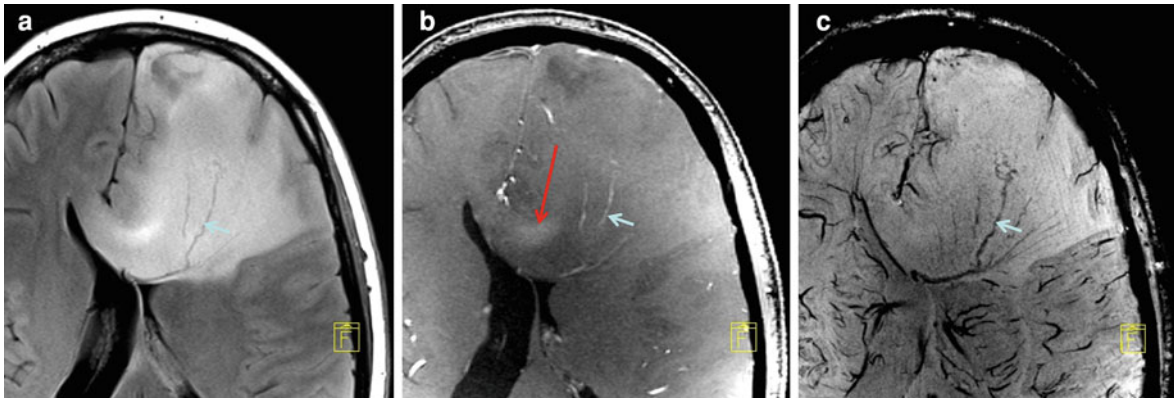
In another case of left frontal Oligodendroglioma, FLAIR shows the hyperintense infiltration of the corpus callosum (a, TR 12,000, TE 83, TI 2760 ms, matrix 512×298 , FoV 230×179 mm, slice thickness 2 mm), and T₁ after i.v. Gadolinium (b, T1-FLASH 3D, TR 6.6, TE 2.4 ms, matrix 448×448 , FoV 230×230 mm) shows a contrast
